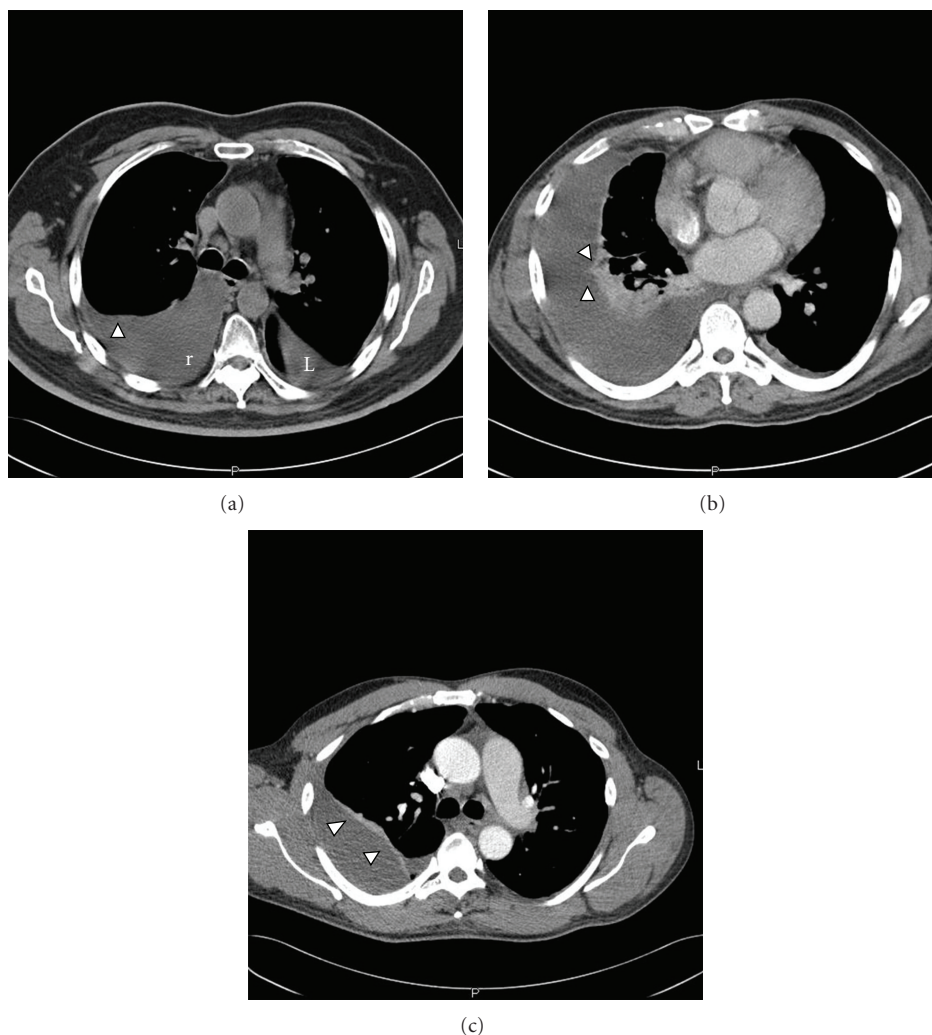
A series of CT images done in patient with parapneumonic effusions. (a) CT image showing a free flowing pleural effusion (r) with a meniscus formation (arrow). There is also some fluid in the fissure on the left side (L). (b) A loculated pleural effusion with loculations seen in the pleural space (arrows). (c) A chronic pleural effusion showing marked pleural thickening (arrows).
